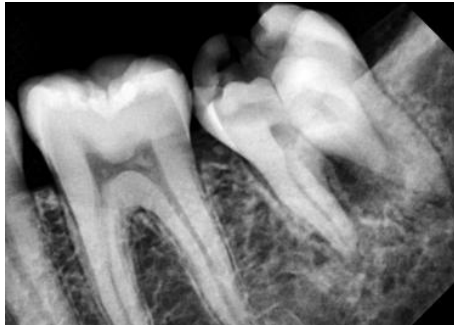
Preoperative radiograph of radix with tooth 37
